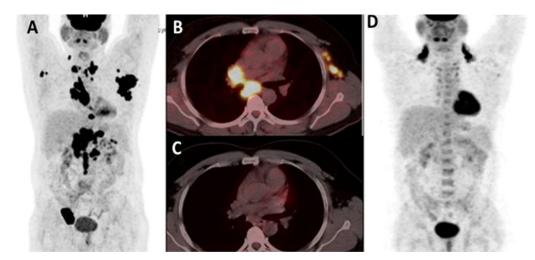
Before ATT showing multiple lesions of intense FDG uptake in cervical, axillary, mediastinal, abdominal and inguinal lymph nodes (A and B). After 6 month of ATT all pathological foci showed complete metabolic response (C and D).
